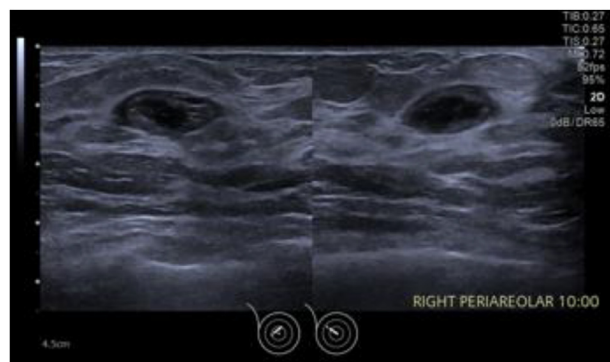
Ultrasound showed a circumscribed oval anechoic mass with thick wall at 10 o'clock periareolar region. No posterior features.
